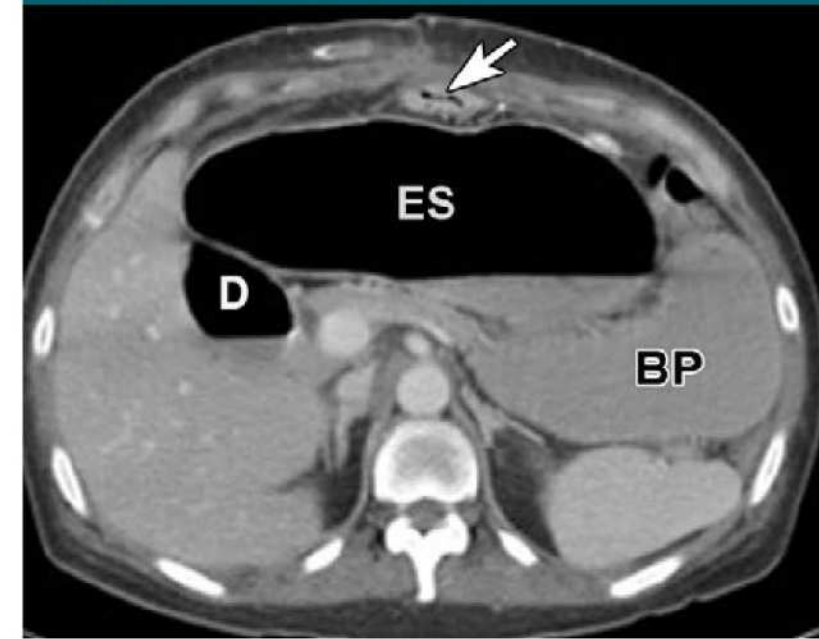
Roux-en-Y gastric bypass with obstruction of biliopancreatic limb. Axial CT image after oral and intravenous contrast material administration shows a dilated, gas- and fluid-containing excluded stomach (ES), duodenum (D), and biliopancreatic limb (BP). The excluded stomach should be collapsed after Roux-en-Y gastric bypass. Recognition of surgical anatomy and collapsed jejunal Roux limb (arrow) is essential for establishing the diagnosis of this closed-loop obstruction.
